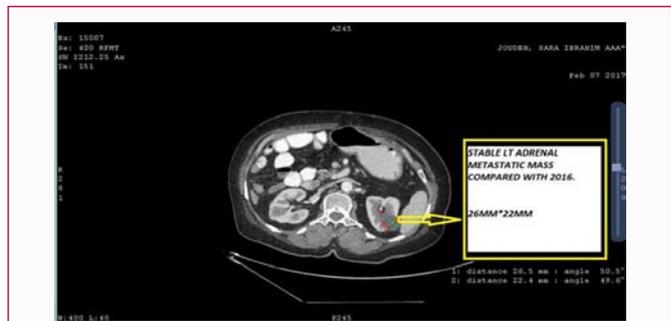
CAP-CT scan was revealed left adrenal lesion (2.2*2.6 cm) on Feb /2017.
